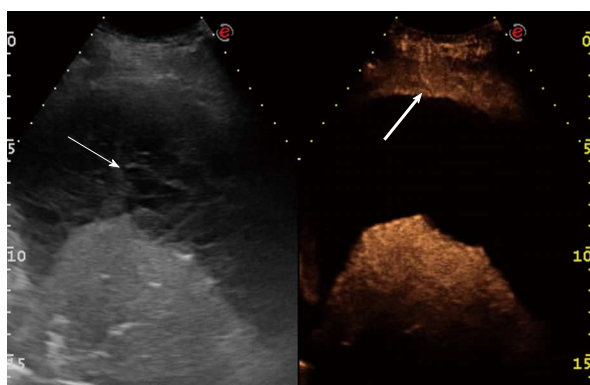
Marked and homogeneous arterial enhancement. Left side of the split-screen: transverse sonogram of the left chest wall in the sixth intercostal space showing loculated pleural effusion (thin arrow) and pulmonary consolidation. Right side of the split screen: contrast-enhanced sonogram showing homogeneous and marked enhanced of the pulmonary consolidation with respect to the chest wall (large arrow). Final diagnosis was compressive atelectasis.
